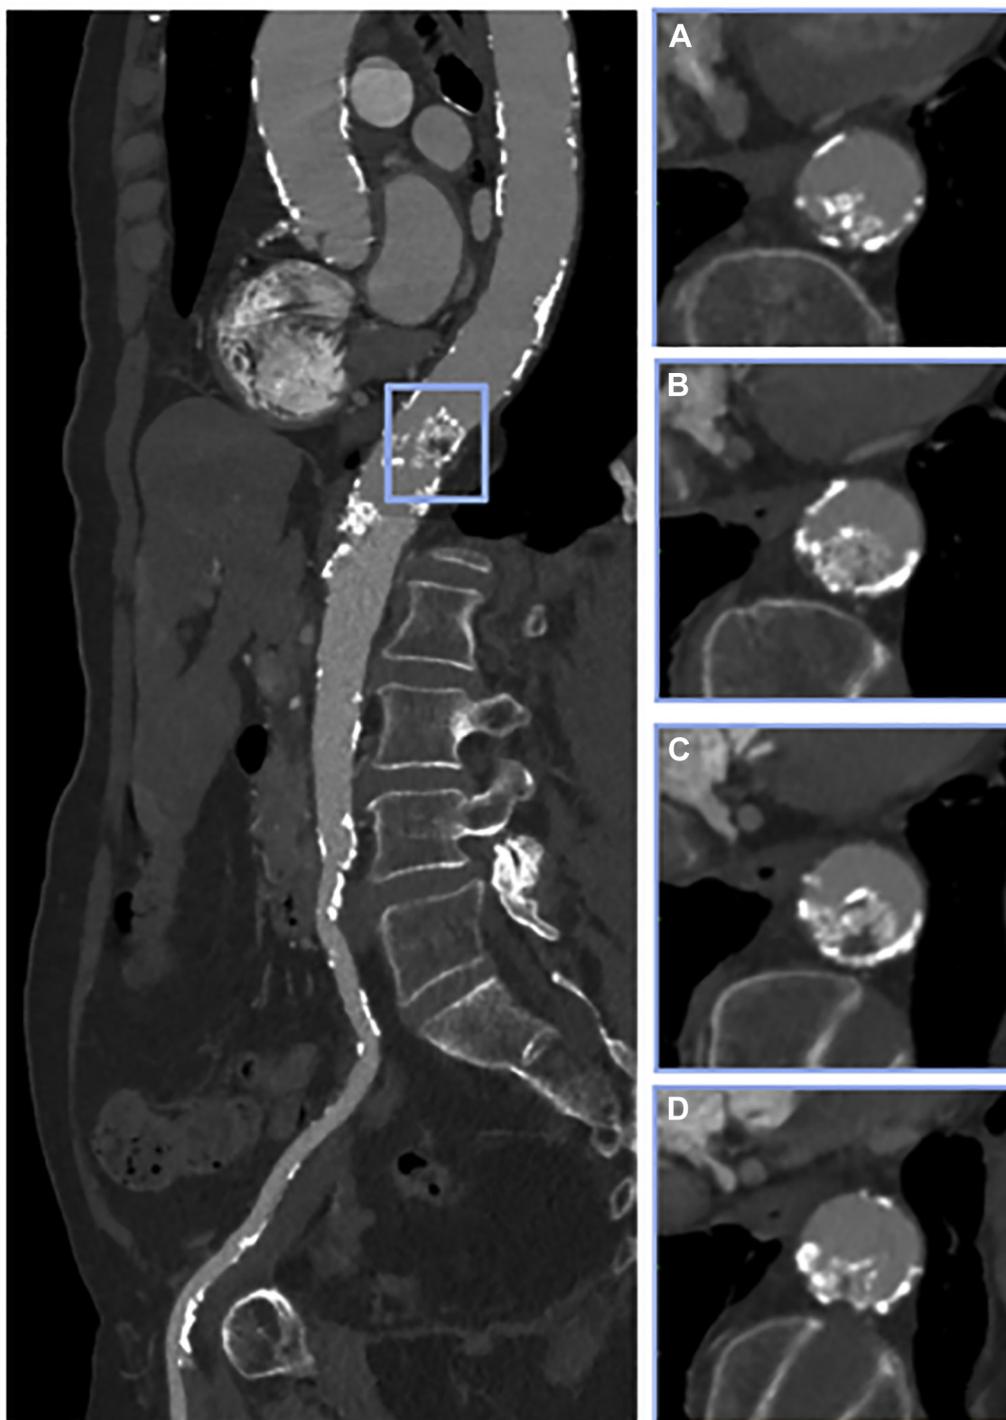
Computed tomography scan evaluation of the aorta. This sagittal plane evaluation showed diffusely calcified aorta and a calcific plaque at the thoracoabdominal transition point with the typical “coral reef” appearance. (A-D) The bulky plaque with subsequent lumen narrowing.
